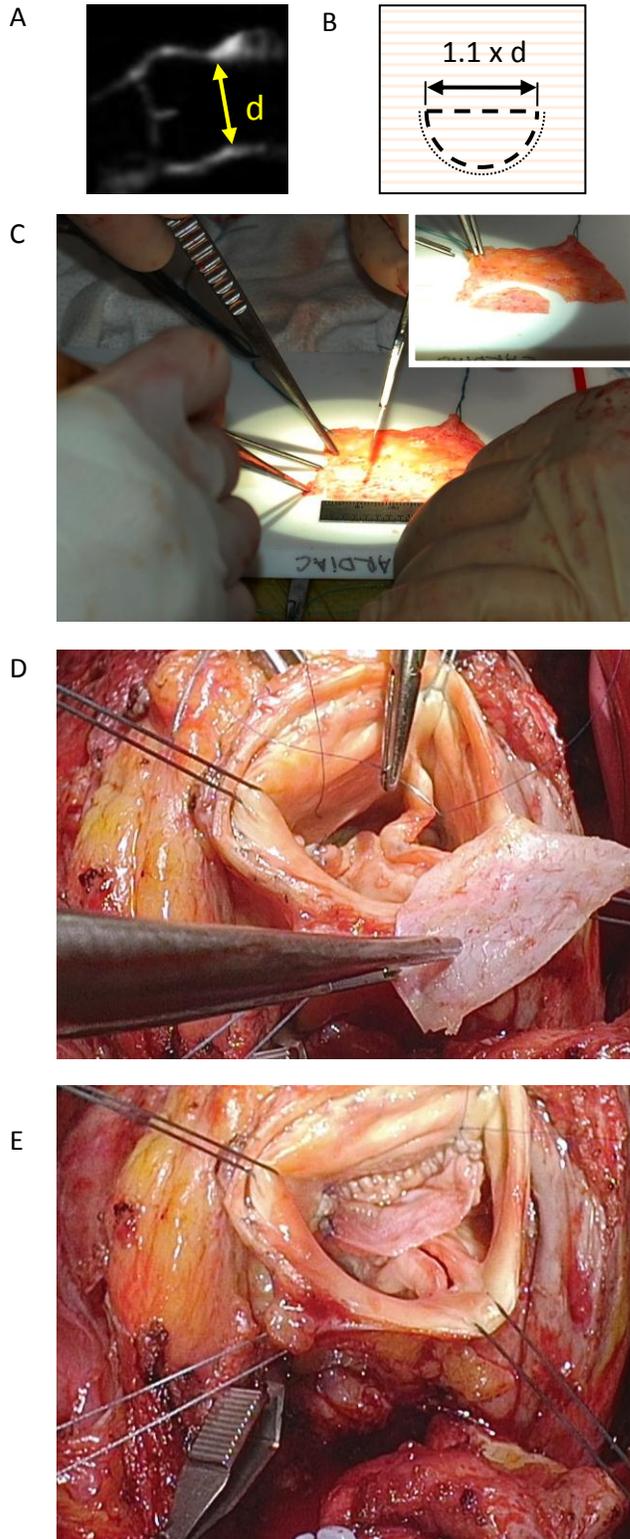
A) Diameter of sinotubular junction, d , is measured from echocardiographic image. B and C) Graft is cut from treated pericardium in the shape of a semicircle with diameter approximately 10 % greater than d , and a 1 mm margin is added along the semicircumference for suturing (dotted line). D and E) Graft is sewn in with a running suture.
